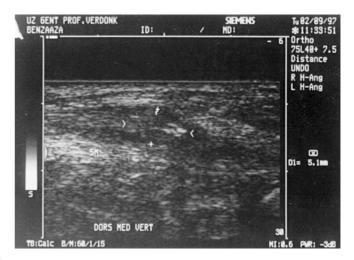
Sonographic image showing a subcutaneous foreign body at the posteromedial corner of the knee, probably representing a small part of the implant that has migrated into the soft tissue
